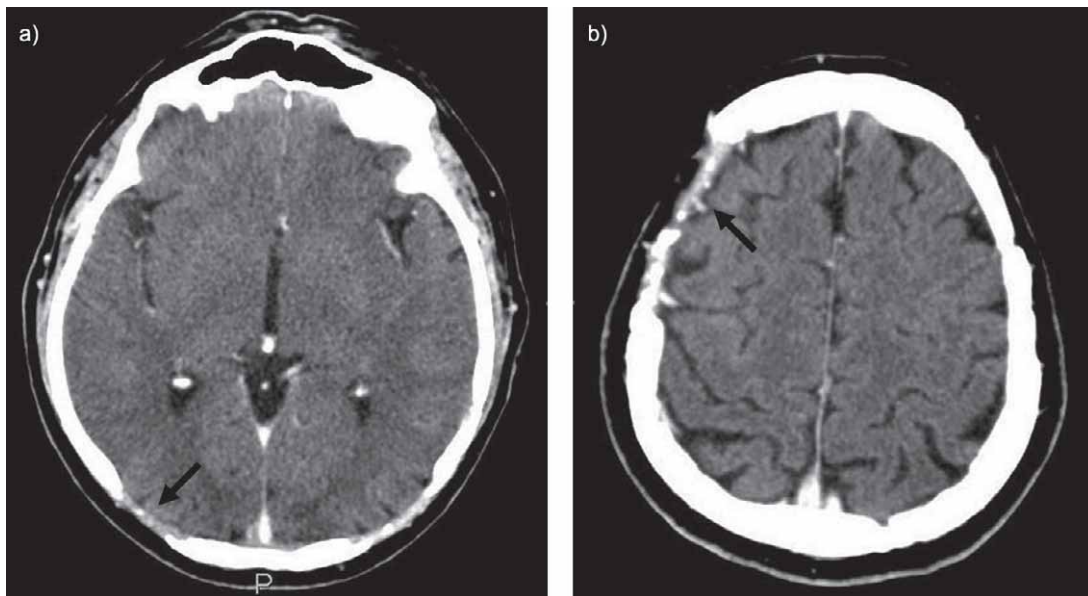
a) PET-CT showing persistent confluent lesions of calvariae crani (arrows). b) Extensive destruction of frontal bone
